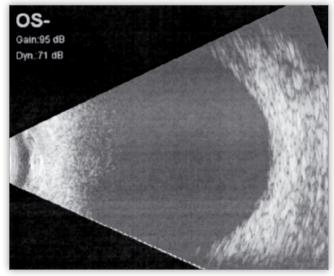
Ultrasound exam of the fundus 4 weeks after surgery – lack of choroidal detachment.
